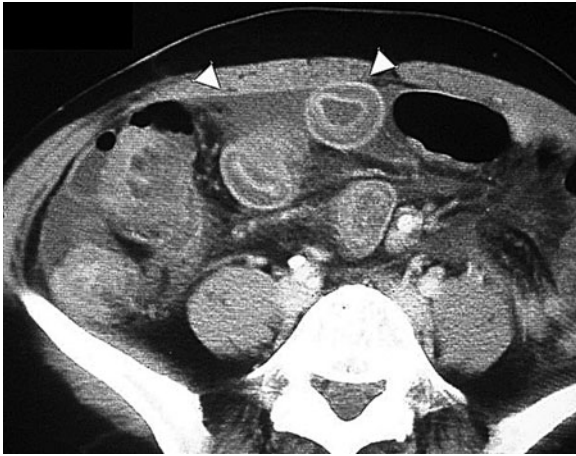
CT scan of intestinal anisakidosis: localized submucosal oedema of the intestinal wall, dilation of the small bowel or ascites are seen (white arrowheads).
